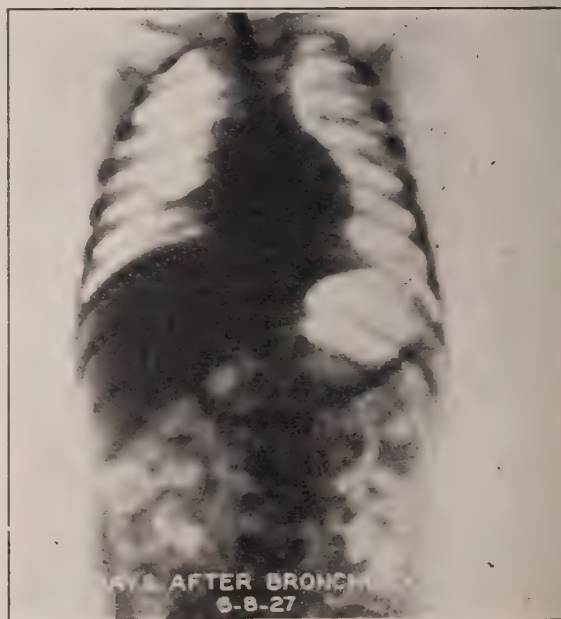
Radiograph four days following bronchoscopic removal of one-half of the bean. The right main bronchus was uncorked, thereby restoring ventilation and drainage. Note (a) normal position of heart, mediastinum and diaphragm normal. (b) Transparency of right and left lungs.
